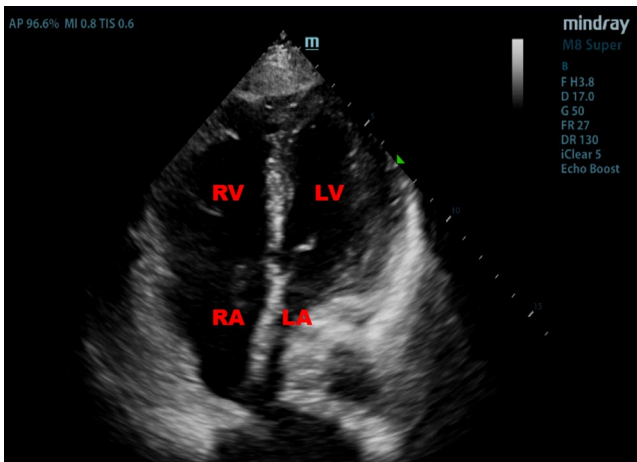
Right heart enlargement in a patient with COVID-19. Legend: Using RC-B-TTE, the enlarged right heart in a critical patient with COVID-19 was confirmed visually by the experienced remote consultants, which was missed by the frontline echocardiographer. This static image was obtained from the echocardiographic video using “Print Screen”. RV, right ventricle; RA, right atrium; LV, left ventricle; LA, left atrium. Other abbreviations as in Figure 1
